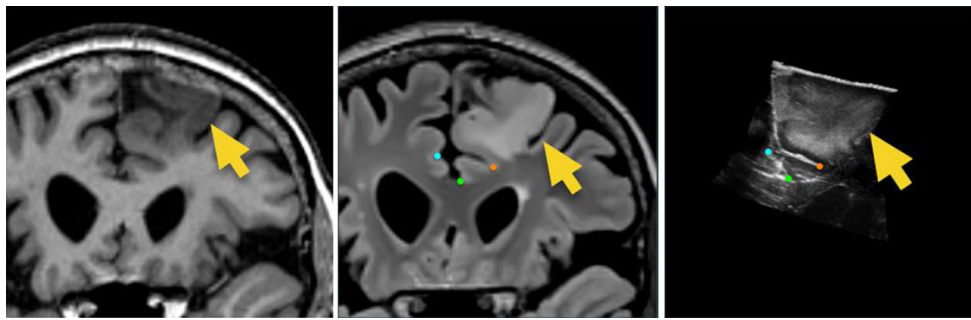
Coronal views of T1w MRI (left), T2 FLAIR MRI (middle), and intra-operative ultrasound scan (right). The yellow arrows indicate the tumor, and the corresponding landmarks between T2 FLAIR MRI
